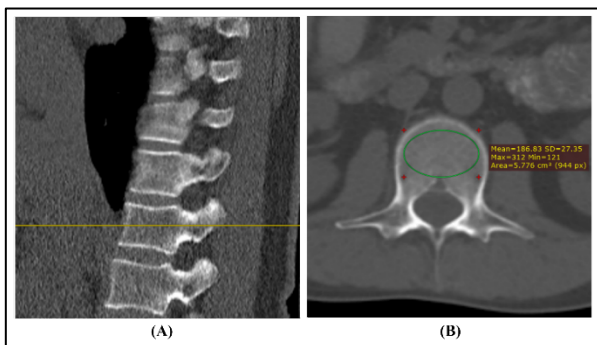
Opportunistic diagnosis of osteoporosis during abdominal CT: (A) Selection of axial image passing from the center of vertebrae, and (B) placement of ROI at axial image to measure mean HU. (50)
